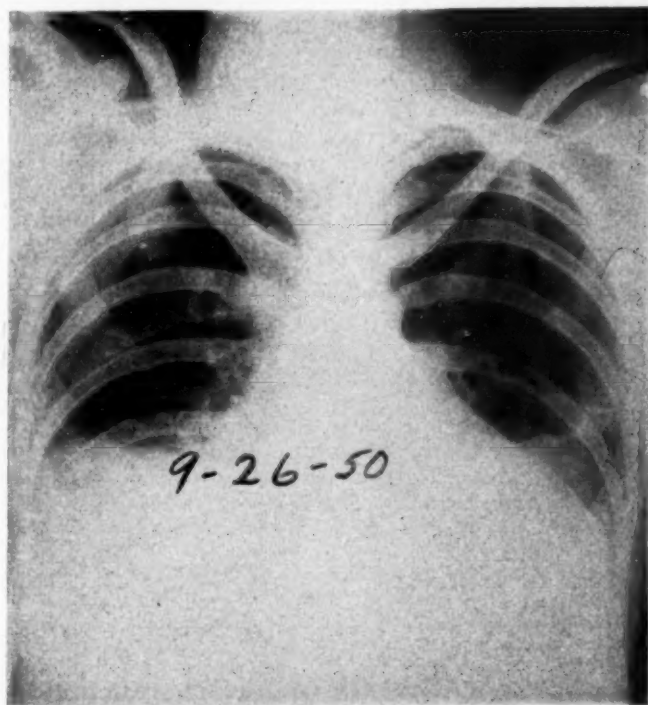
Chest x-ray showing bilateral pleural effusion obliterating cardiac borders, making heart size difficult to determine.
